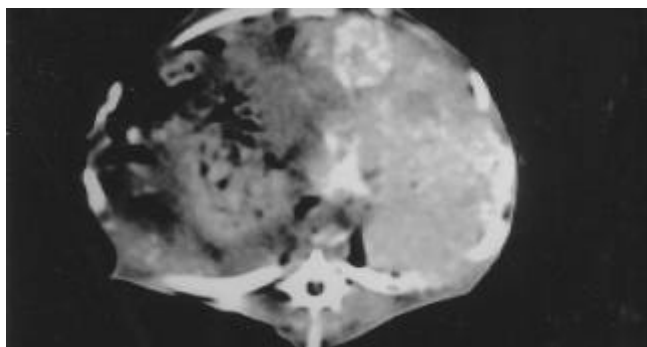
CT scan 2 d following lipiodol infusion.
